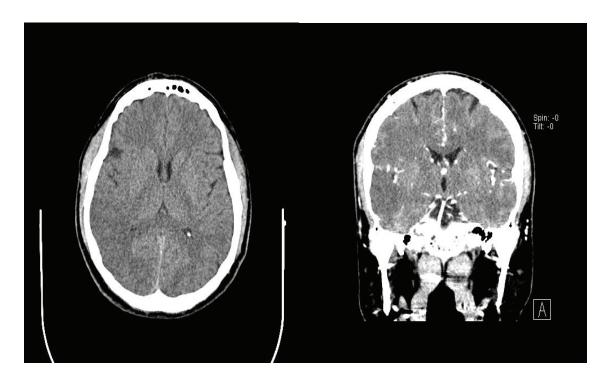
Initial emergancy brain CT (45 minutes after the onset of symptoms). Figure 2. Emergancy CT angiography (45 minutes after the onset of symptoms).
